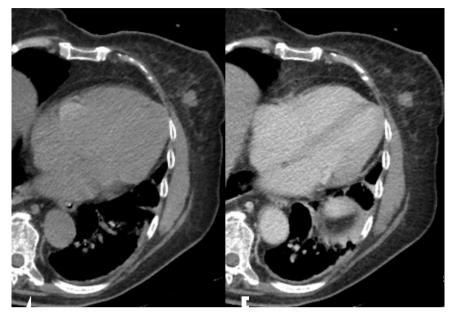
Pre- and post- IV contrast axial chest CT.
